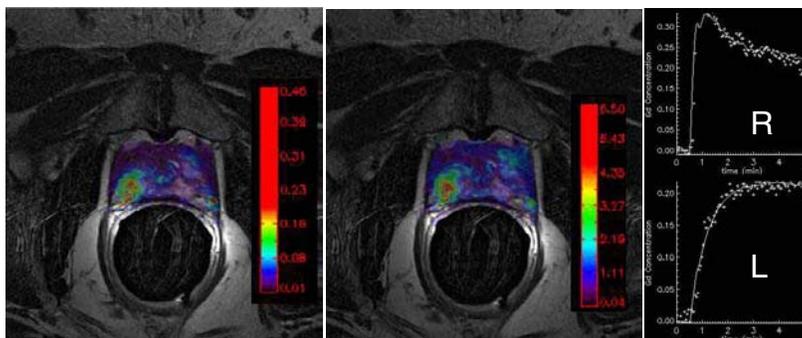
DCE-MRI parametric maps superimposed on T2W image and gadolinium concentration-time curves in malignant (right side) versus benign prostatic tissue.
